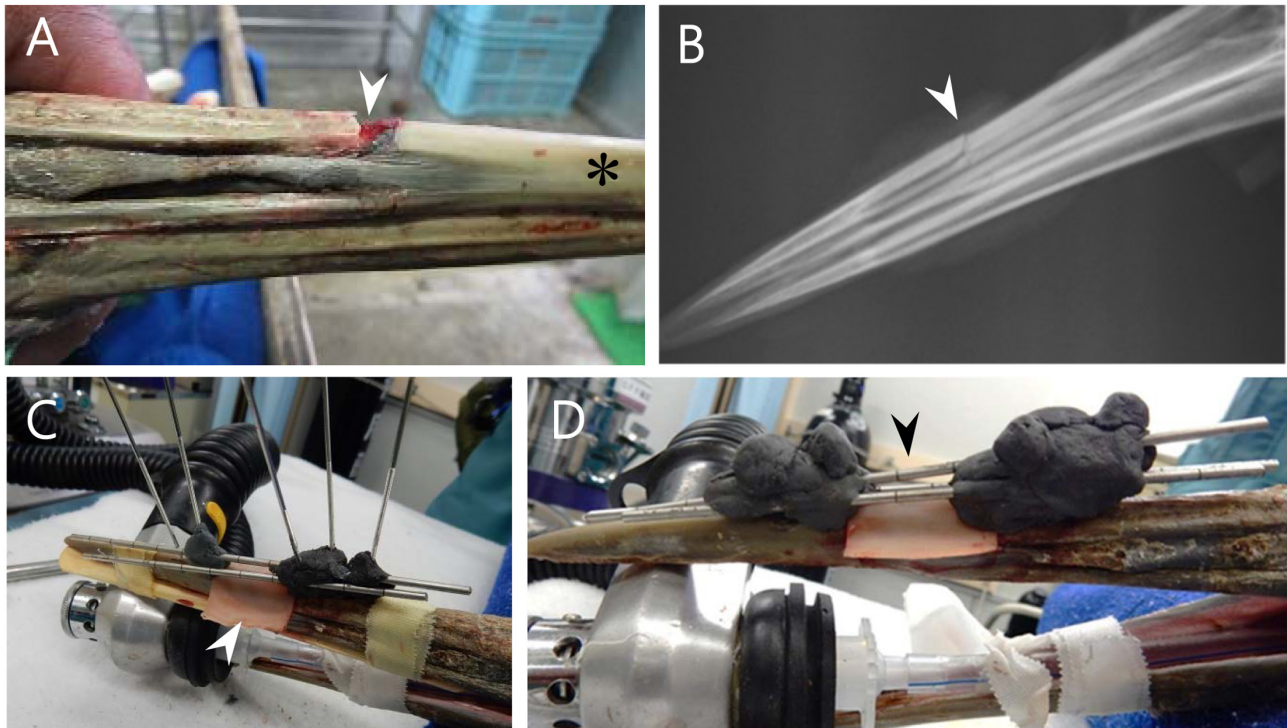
[Day 1] Surgery for treating a middle upper beak fracture by a Type I-a external skeletal fixator (ESF) with a unilateral epoxy putty fixator. (A) Right-side view of the middle upper beak compound fracture. (B) Left-side radiograph of the upper and lower beaks before surgery. (C) The jointing 5 half-pins for the median of the premaxilla with epoxy putty during surgery. (D) The completed ESF placed on the upper beak. The arrowhead shows the site of the middle upper beak fracture (covered with a hydrocolloid plaster in C and D), and the asterisk shows the distal side of the upper beak.
